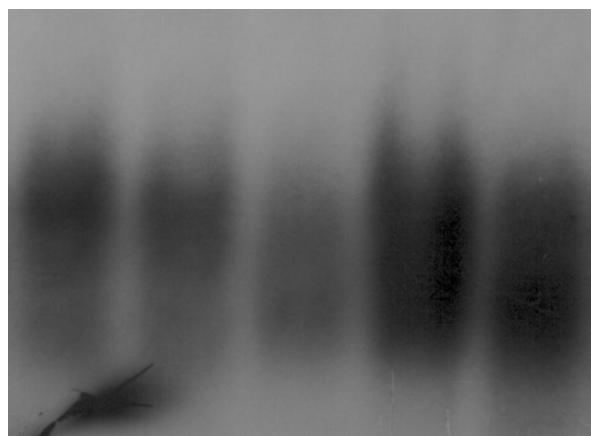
Representative radiographs of NF-kappaB activation in PBMCs of healthy controls. Lanes 1-5.
